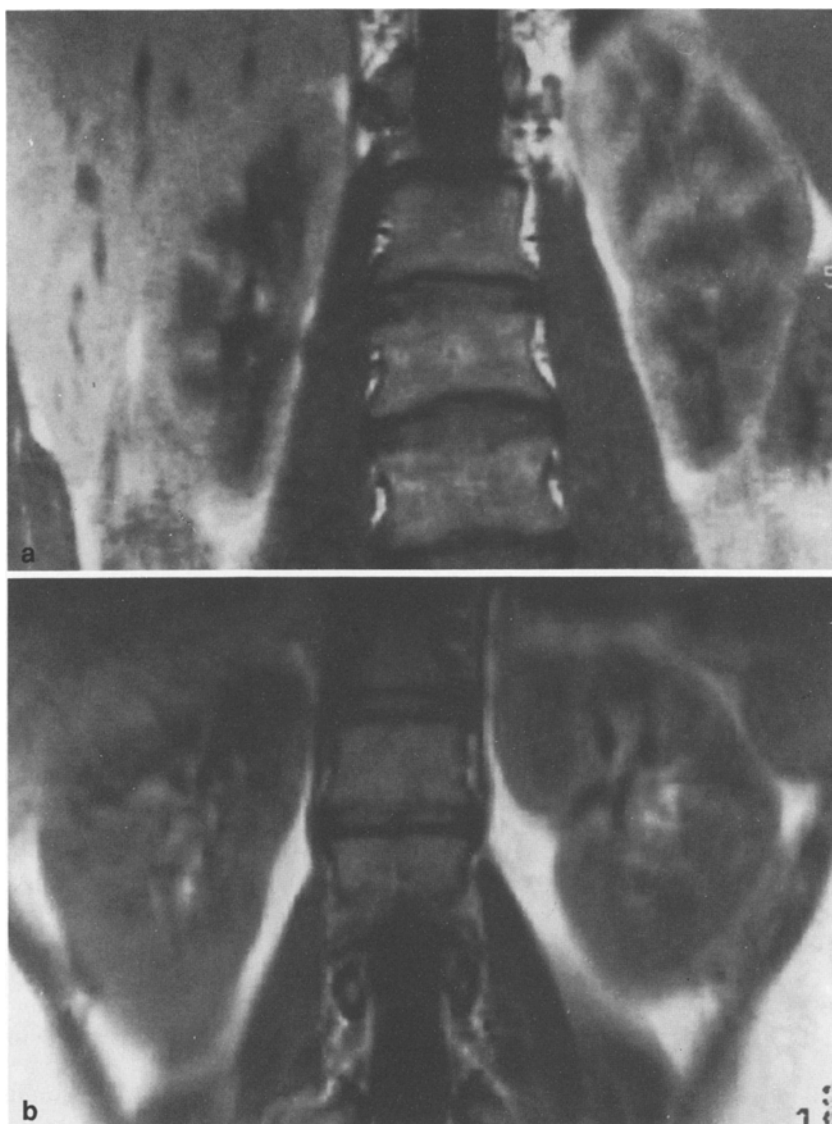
Magnetic resonance images of the kidney in Type 1 (insulin-dependent) diabetes mellitus. a Patient with normal urinary albumin excretion and serum creatinine; the visual contrast between the cortical and the medullary (darker) area can be readily identified. b Patient with overt nephropathy. The visual contrast between the cortical and the medullary area is not easily recognised
